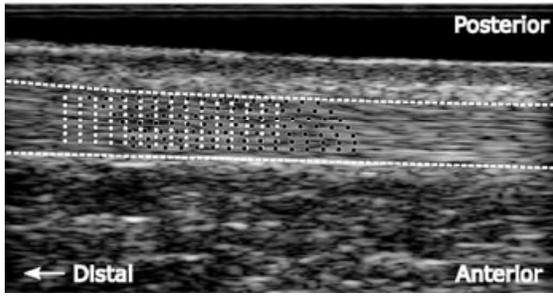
An example of the placement of tracking nodes from a single subject. The ultrasound image shown is from the beginning of the contractions. White dots indicate the locations of the nodes placed over this image. Black dots indicate the locations of the nodes at the instant of peak displacement. White dotted lines depict borders of the tendon. A gel pad and ultrasound gel were used in the sagittal plane between the probe and the skin (dark area in top of the image). In the coronal plane, only ultrasound gel was used.
